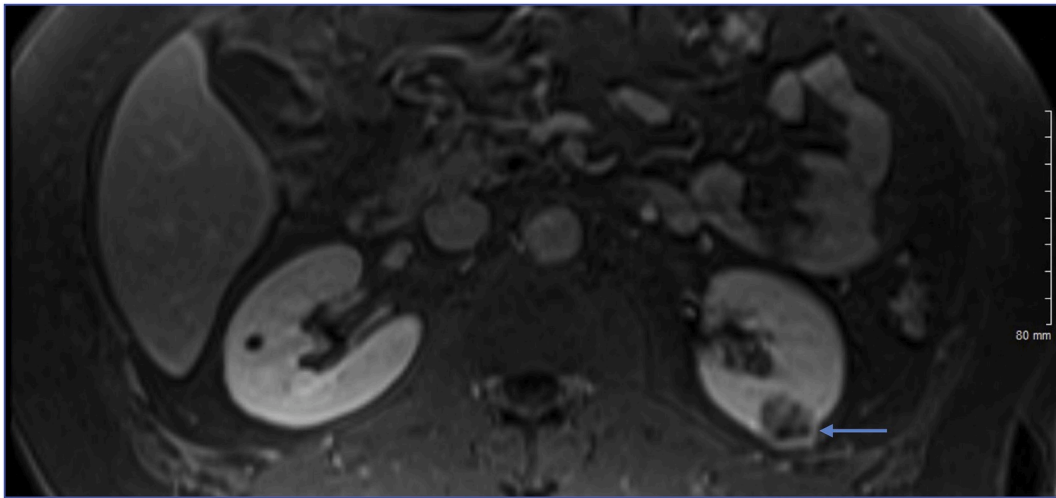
T1 MR image with arrow demonstrating a left lower pole mass with nodular component concerning for malignancy.
